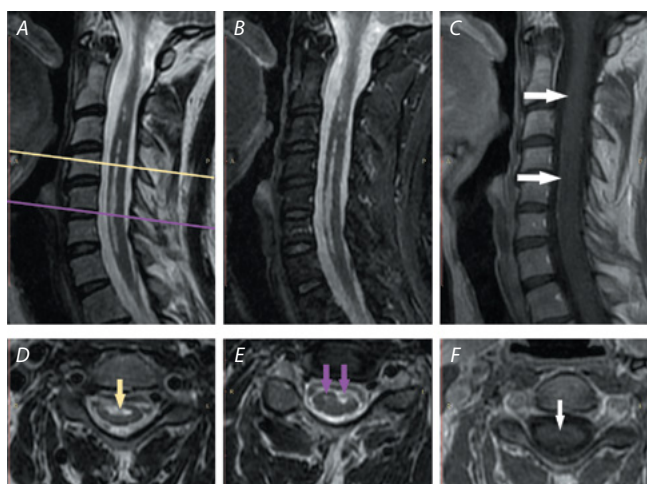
MR image of patient A. with arterial infarction of spinal cord at C2–C3, C3–C7.
